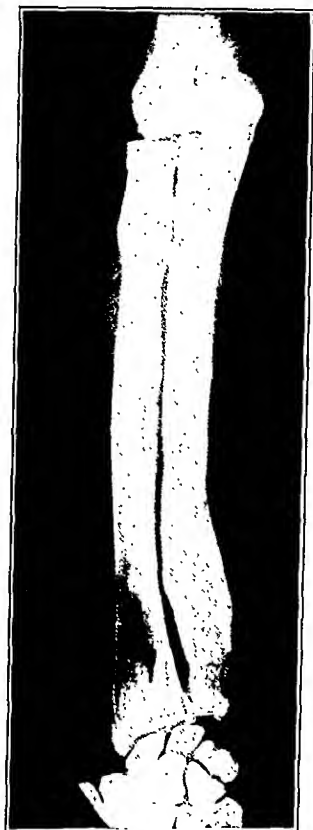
X-ray picture of the right ulna, showing marked calcification of the previously existing fibrocystic changes about eleven months after surgical removal of the parathyroid gland.
